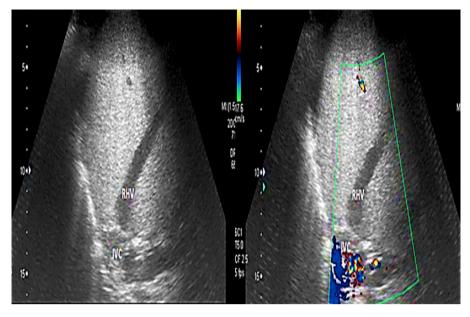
Doppler ultrasound on the first post-operative day denoting absence of flow in the right hepatic vein (RHV: right hepatic vein, IVC: inferior vena cava).
